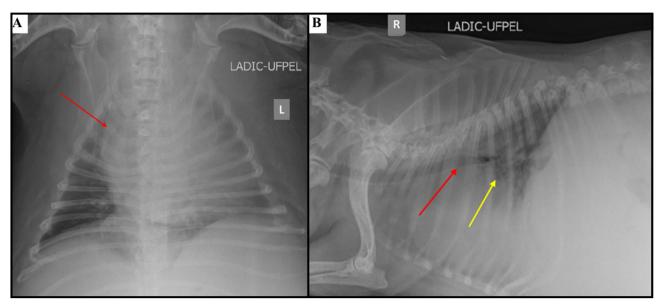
Ventrodorsal thoracic radiography revealed cardiomegaly with displacement towards the left hemithorax (A, red arrow; L, Left) and right latero-lateral view (R) demonstrating dorsal displacement of the trachea (B, red arrow) and a mild peri-hilar broncho-interstitial pattern (B, yellow arrow).
